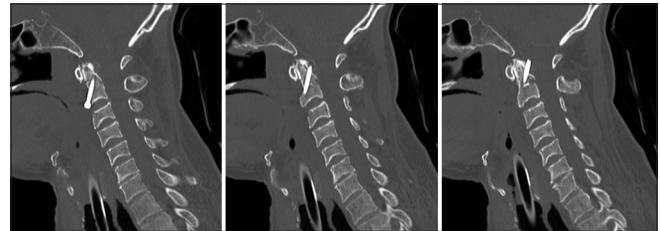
Sagittal immediate post-anterior odontoid screw fixation computed tomography images of the cervical spine, demonstrating near anatomic correction of the patient's type II odontoid fracture with a lag screw.
